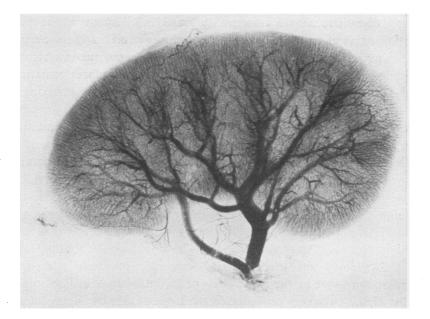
ROENTGENOGRAM OF A NORMAL ARTERIAL TREE (EXPERIMENT 29)
